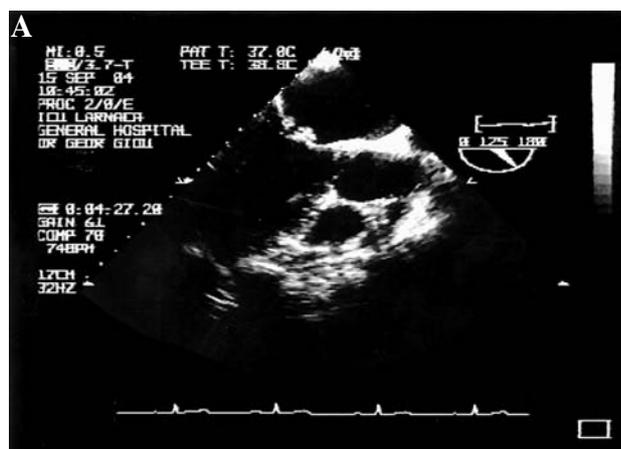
A: Transesophageal echocardiogram (long axis view, 120°) showing large vegetations on both mitral valve leaflets. B: Shows a magnification.
